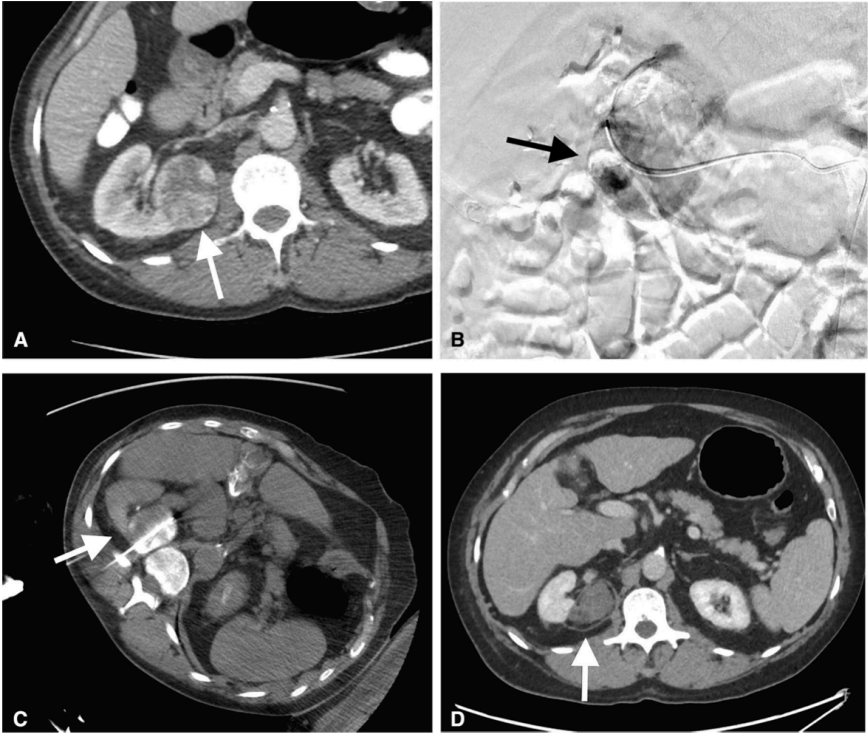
Case 1. 53-year-old male with laryngeal squamous cell cancer status post-resection, adjuvant chemotherapy, and radiation therapy, found to have a right hilar renal mass measuring 5.2 cm, clear cell, renal cell carcinoma, stage T1b. A Pre-procedure axial CT image of the tumor. B Intraoperative fluoroscopic imaging of selective transarterial embolization. C Intraoperative axial CT image of percutaneous microwave ablation. D Axial CT post-procedure follow-up imaging at 19 months
